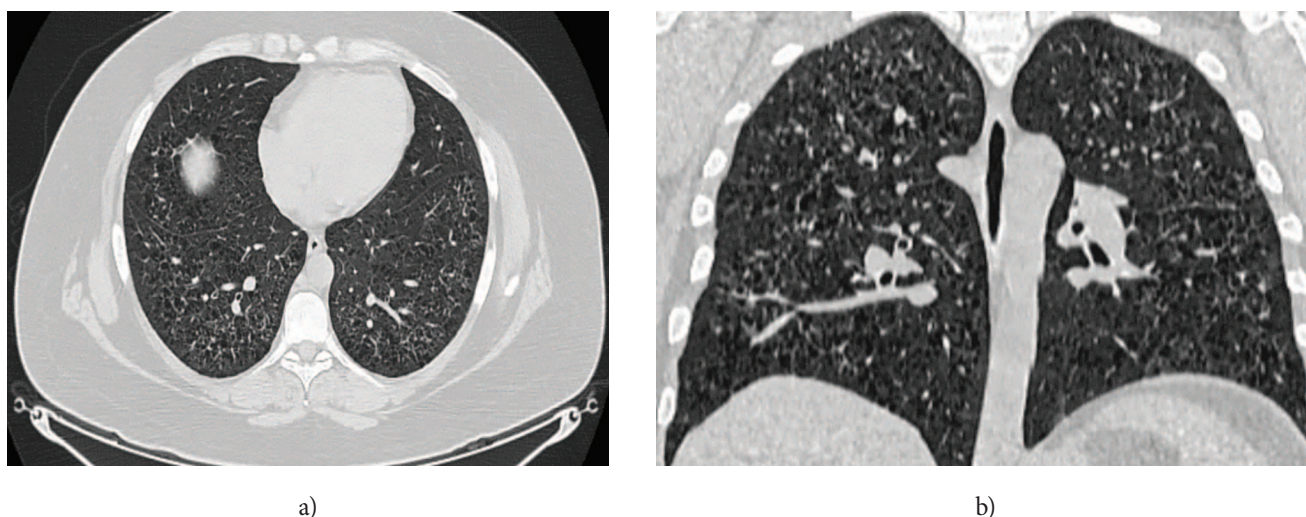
Computed tomography of the chest (a, b)
